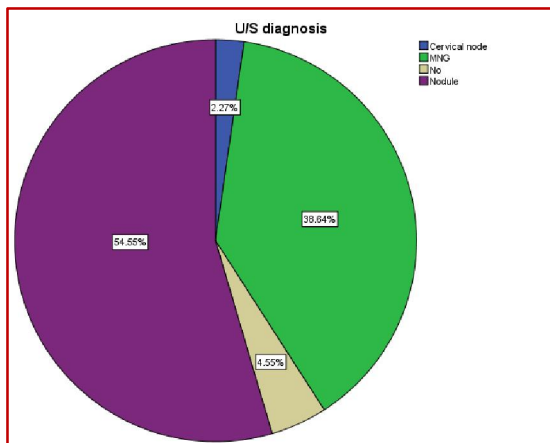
results of ultrasound neck
